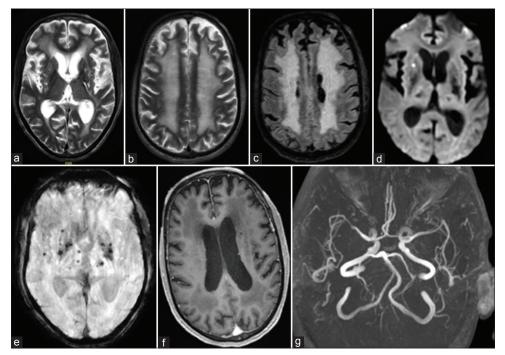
The axial T2 images (a and b) and axial FLAIR image (c) show diffuse confluent periventricular and lobar white matter hyperintensities. Prominent perivascular [Virchow-Robin (VR)] spaces noted at bilateral basal ganglia. The axial diffusion-weighted image (d) shows an acute lacunar infarct at right putamen. The SWAN image (e) shows microhemorrhages at bilateral basal ganglia and thalami. The postcontrast T1MPRAGE (f) and TOF MR (time of flight magnetic resonance) angiogram (g) are unremarkable. The image features are consistent with diffuse small-vessel disease
